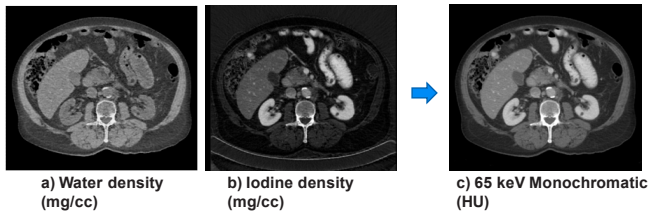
Reconstruction of monochromatic energy image from a pair of basis material density images. The monochromatic energy image, which represents attenuation data that would be measured with a mono-energetic X-ray source at any specific keV level, is computed by combining the basis material density images using Equation 8.
